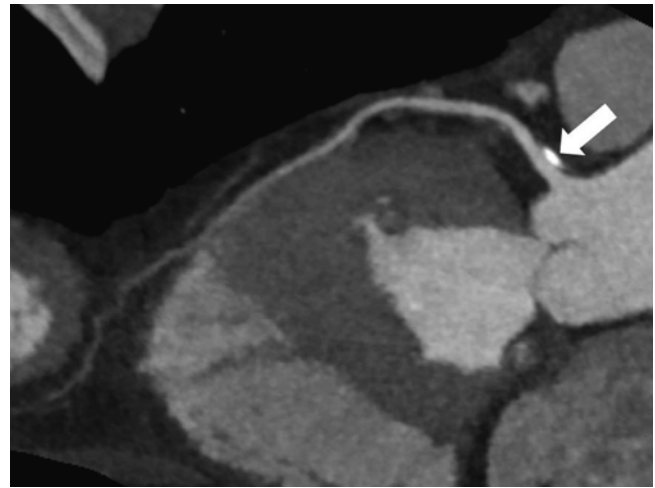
Insignificant luminal narrowing of the coronary artery with a marginal plaque. Bidimensional MPR image (B-MPR) of LAD on coronary CTA shows marginal calcified plaque (white arrow) in pLAD
